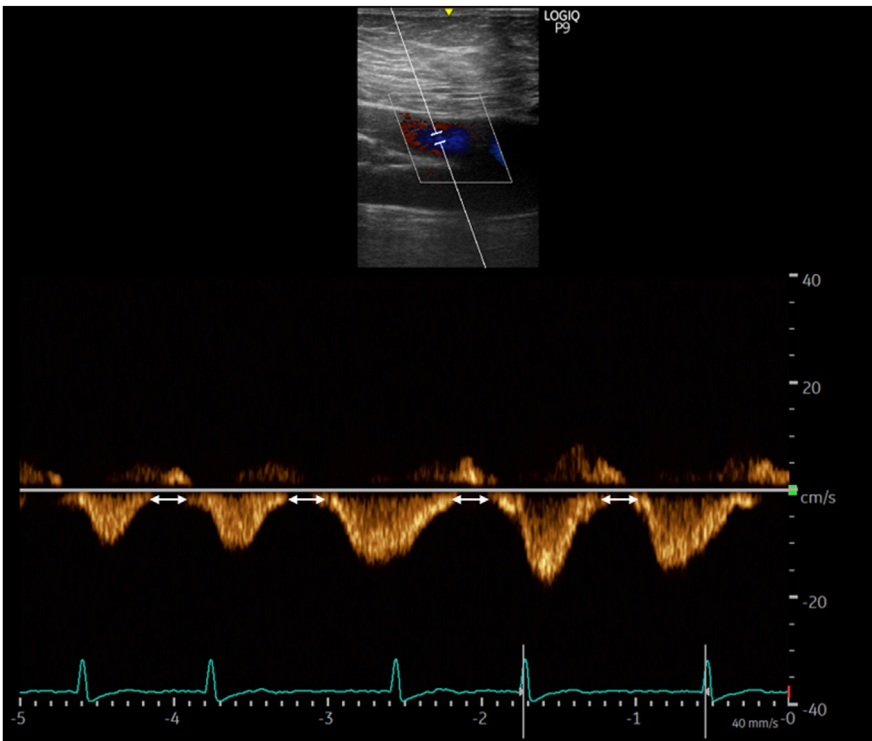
Baseline 2D-guided color-flow and pulsed-wave Doppler, right lower extremity, femoral vein spectral display, demonstrates a highly pulsatile waveform with significant flow interruptions (*white arrows*) and prominent retrograde waves above the baseline (*yellow arrows*) suggestive of severe venous congestion.
